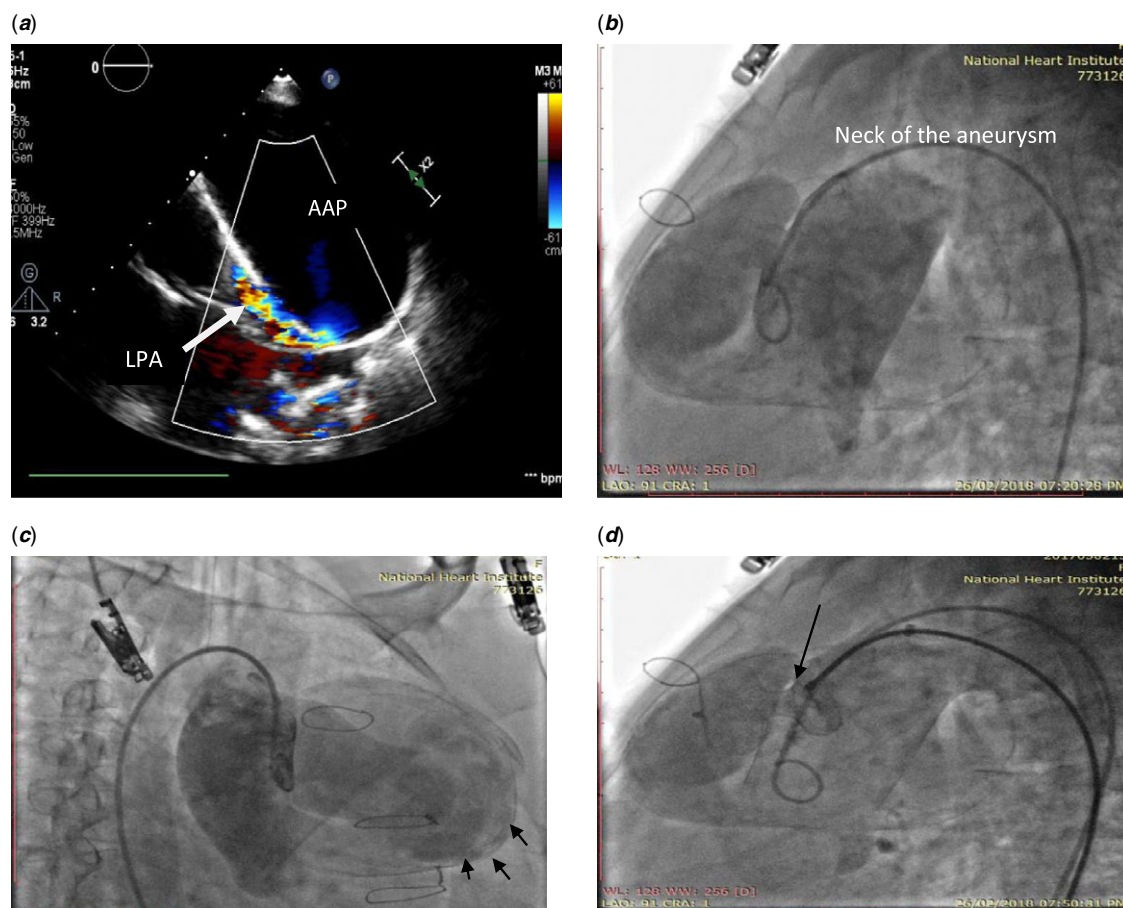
(a) Transthoracic echocardiogram (parasternal long-axis view) showing a giant ascending aorta pseudoaneurysm fistulating into the left pulmonary artery. (b) An ascending aortic angiography in left lateral view has minimised overlap of the ascending aorta and the cavity of the AAP. (c) Angiography in RAO projection revealed the large AAP extending to the left of the upper ascending aorta with its cavity edges marked by arrows. (d) The bulkiness of the device (arrow) was the result of oversizing needed to stabilise the left atrial disc in AAP cavity.
